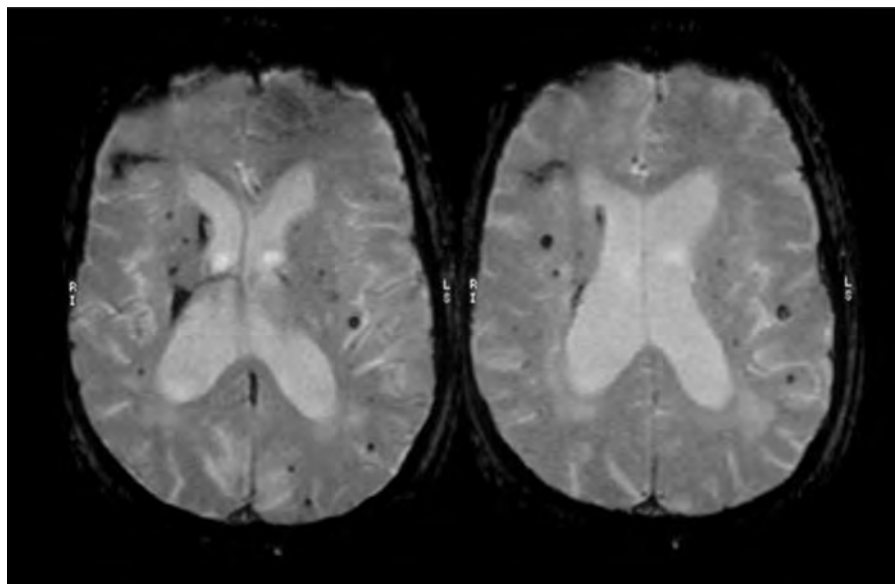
Multiple microhaemorrhages (MRI T2W).
